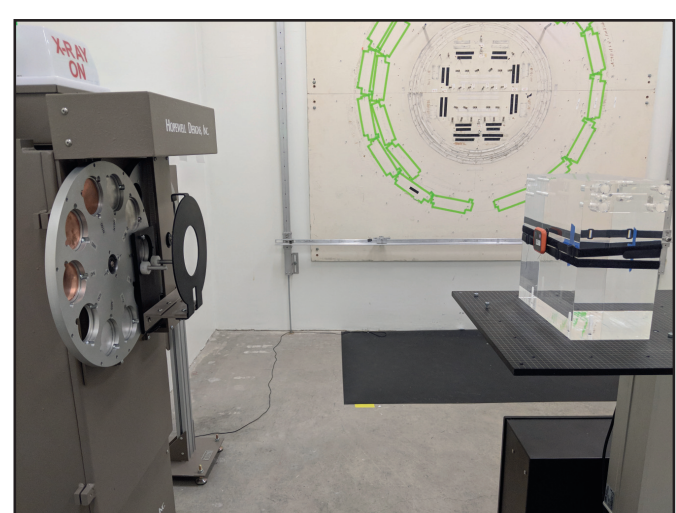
X-ray exposure set-up using a Hopewell X80-225kV irradiator (N-series exposures).
